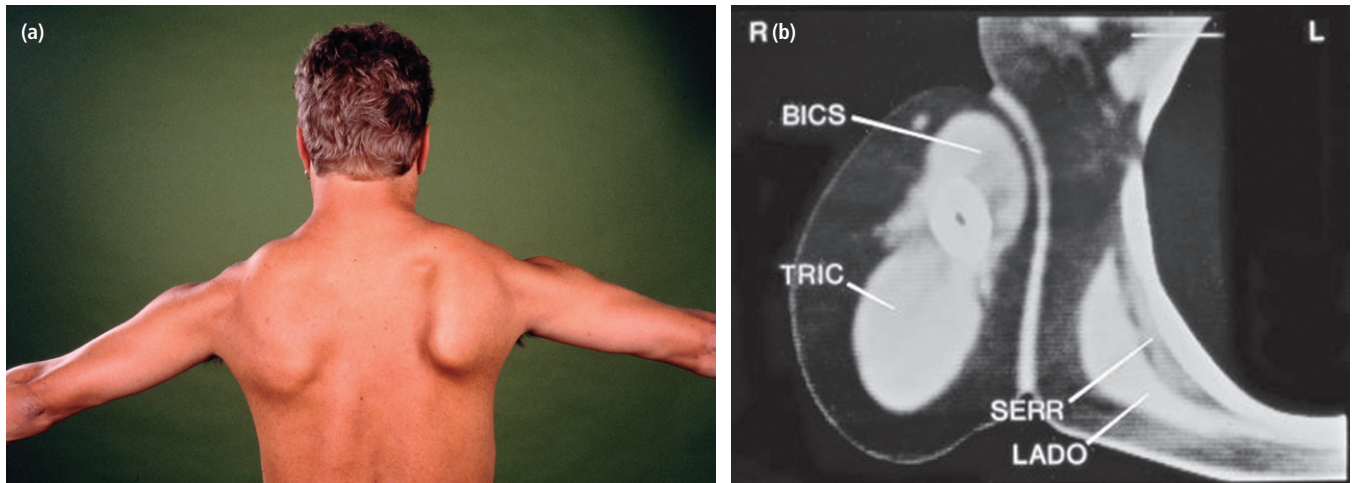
Facioscapulohumeral dystrophy. (a) Winging of the scapulae when the patient lifts his arms, right more than left. (b) CT scan reveals preferential involvement of the right serratus anterior muscle. BICS, biceps; LADO, latissimus dorsi; SERR, serratus anterior; TRIC, triceps.
